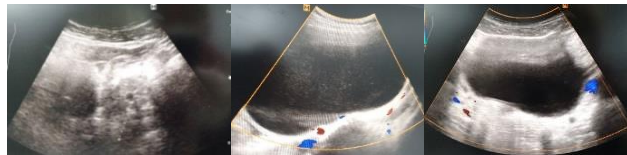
Pelvic ultrasound examination revealed an enlarged pelvic mass edema and Doppler imaging showed flow in the wall with negative intra-cyst. Solid mass (6 cm) was found in the right ovary and another mass (3 cm) was found in the left ovary.
